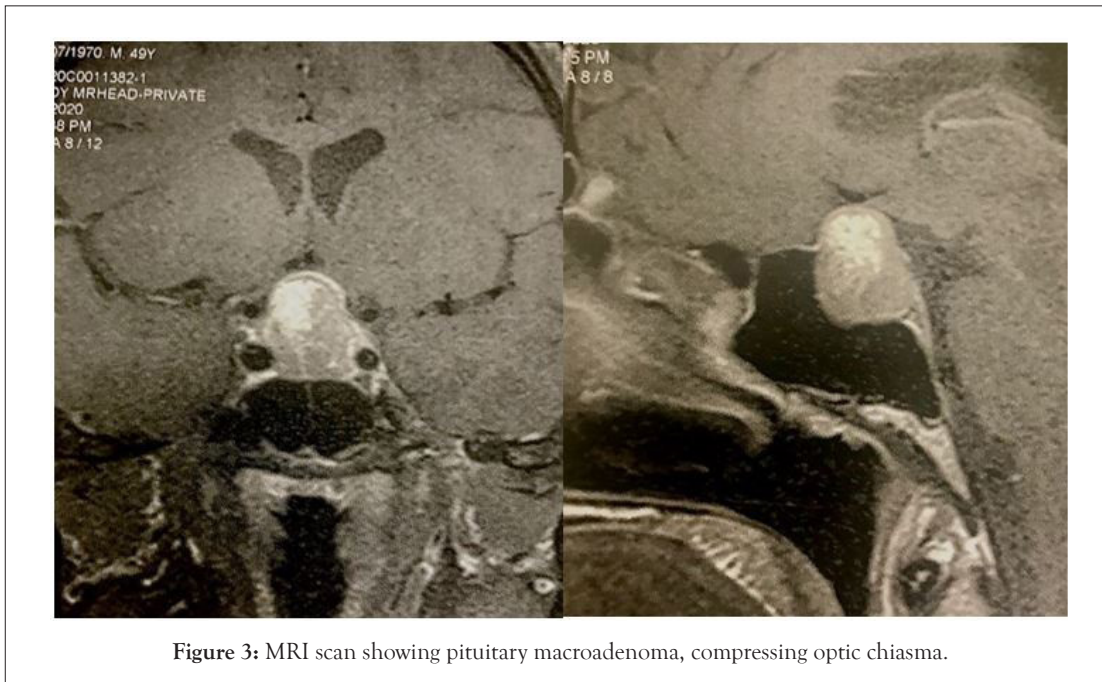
MRI scan showing pituitary macroadenoma, compressing optic chiasma.
